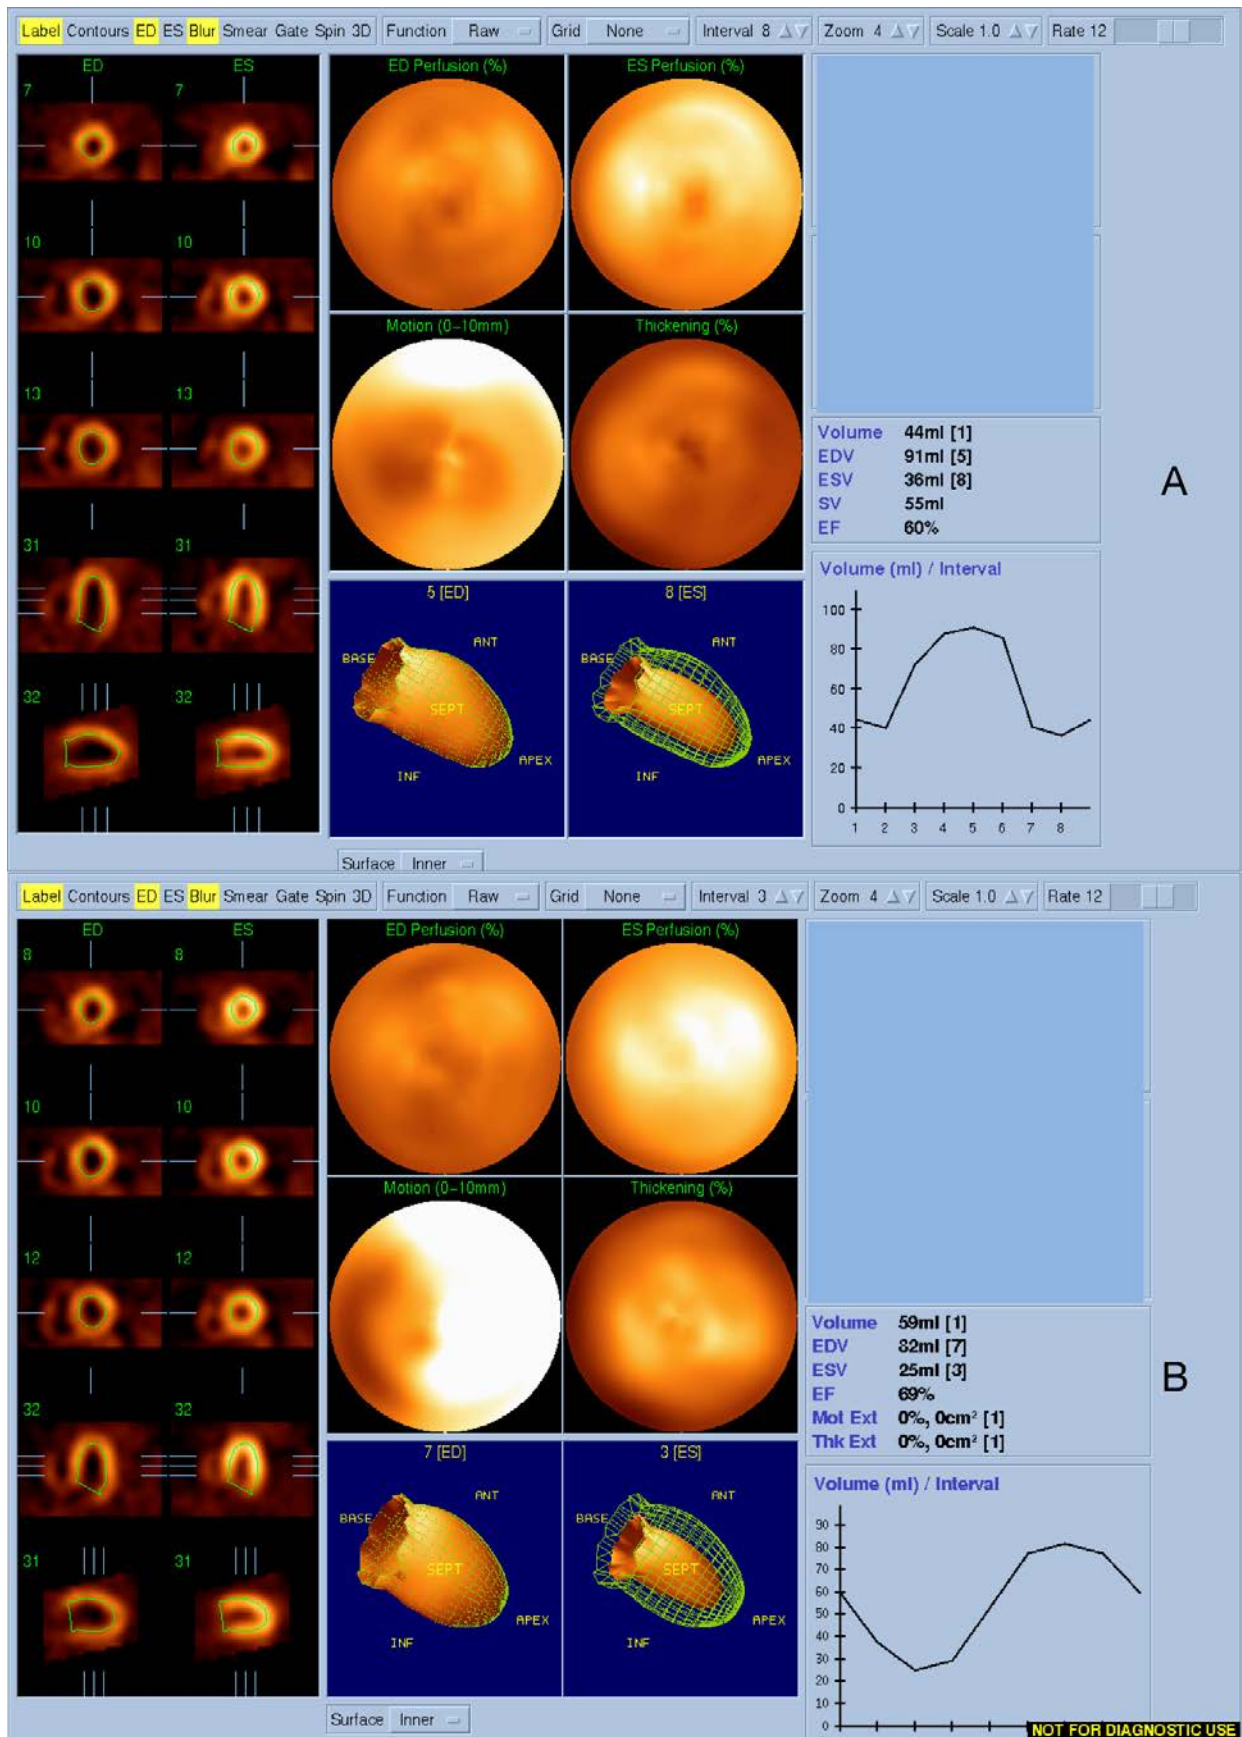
Myocardial perfusion SPECT study. (A) Patient with arrhythmia demonstrating a poor representation of the myocardial cycle. (B) Once the arrhythmia has been resolved, the gated data are better represented.
